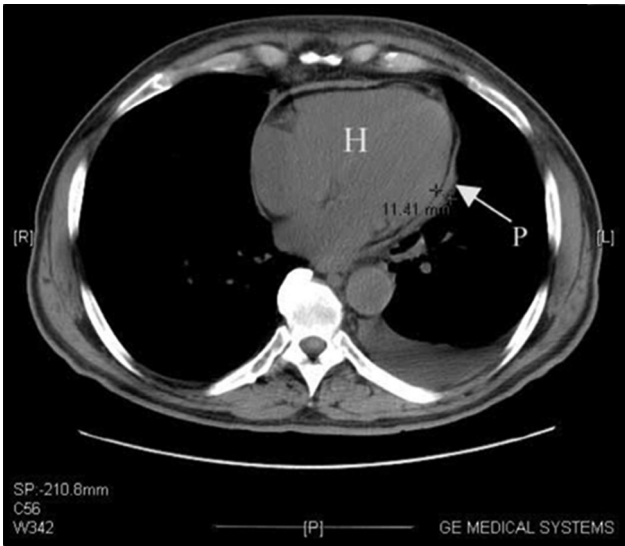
Computed tomography (CT) of the heart (H) showing a thick pericardium (P; arrow).
